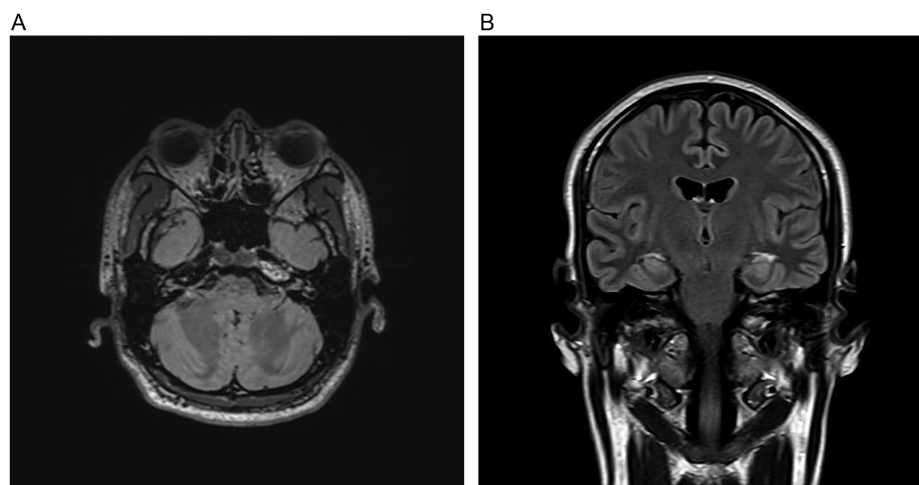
Axial (A) FLAIR sequence of patient no. 11. Each inner ear was rated 3, marked enhancement. The patient did not develop hearing loss. Coronal (B) FLAIR sequence of patient no. 15. The right inner ear was rated 0, no enhancement, and left inner ear was rated 1, mild enhancement. The patient developed left-sided mild-to-moderate hearing loss. FLAIR, fluid-attenuated inversion recovery.
